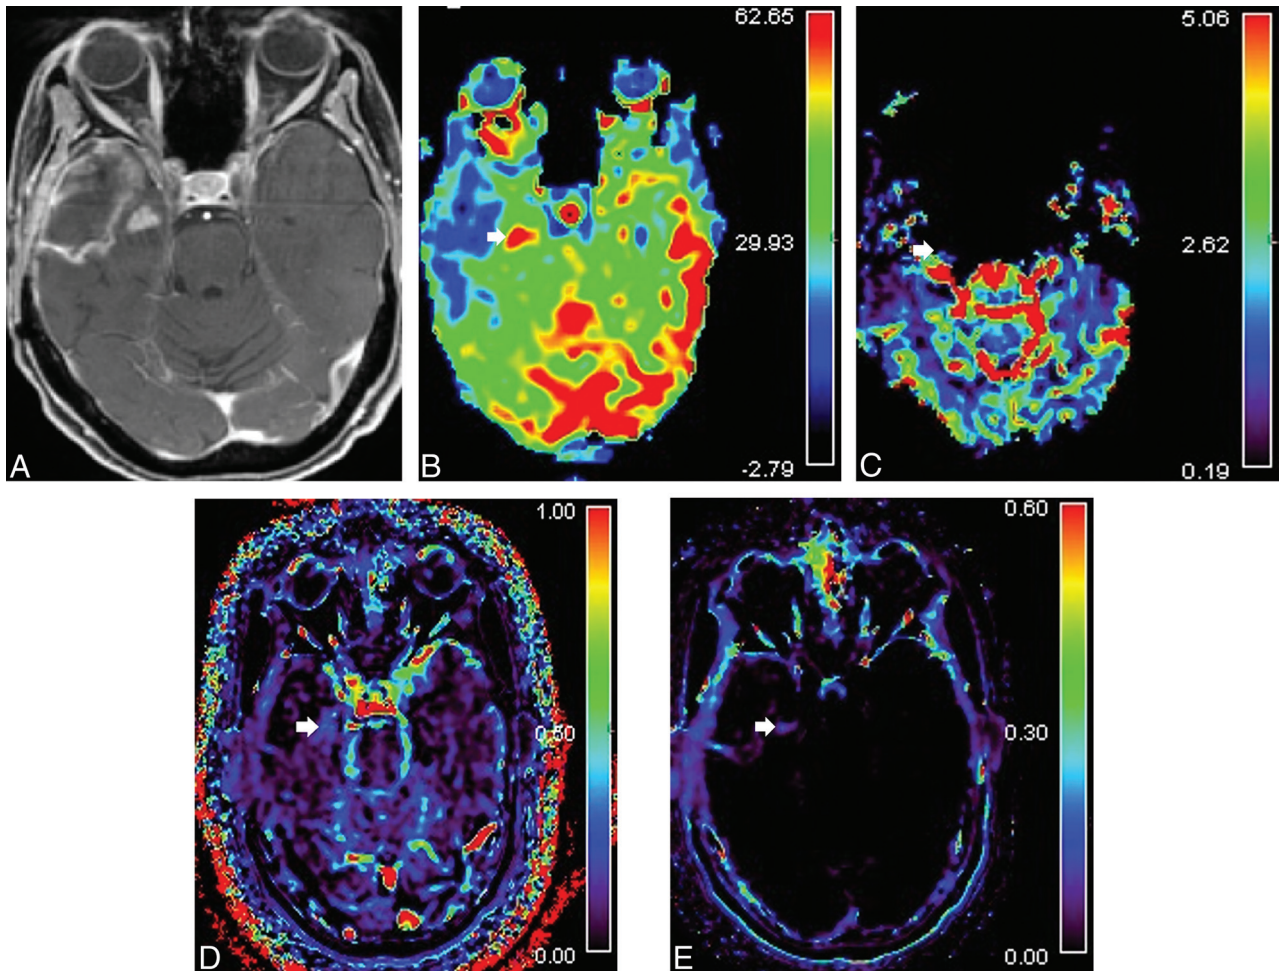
Example of a case of recurrent glioblastoma multiforme with a false-negative DSC study due to susceptibility artifacts. *A*, Axial T1-weighted image shows a newly enhancing lesion in the right mesial temporal lobe. *B*, ASL-derived CBF map demonstrates a marked increase in CBF in the lesion (*arrow*). *C*, Corrected CBV map is unreliable in the tumoral region due to susceptibility artifacts (*arrow*). DCE MR imaging performed without T1 mapping reveals high V_p (*D*) and K^{trans} (*E*) values in the lesion (*arrow*), which correlate with the high CBF value.
